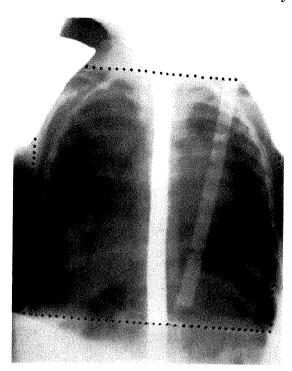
Posterior treatment portal employed for Wilms' tumor metastases in the lungs. Lead shields protect the shoulders, midline of the back and spinal cord. A double exposure technique is used in taking the roentgenogram. The smaller, darker image (dotted lines) is that of the treated area. The larger, lighter exposure includes more anatomic landmarks to assist in orientation. A lead ruler notched at 1 cm. intervals is placed on the entry skin surface. It provides an easy means of correction for magnification when changes in size or alignment of the field are to be made, as in this case where minor changes were necessary in the positioning of the shoulder protectors and in the width of the field to the left.
